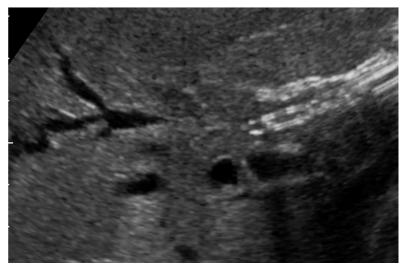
Diagnostic sonography guided puncture with visible tip of 0.9 mm needle, stent after EPT in stenosis, rare case of autoimmune cholangitis (sustainable improvement and stent removal as well as complete normalization with 50 mg steroids for 8 weeks); SCS right
